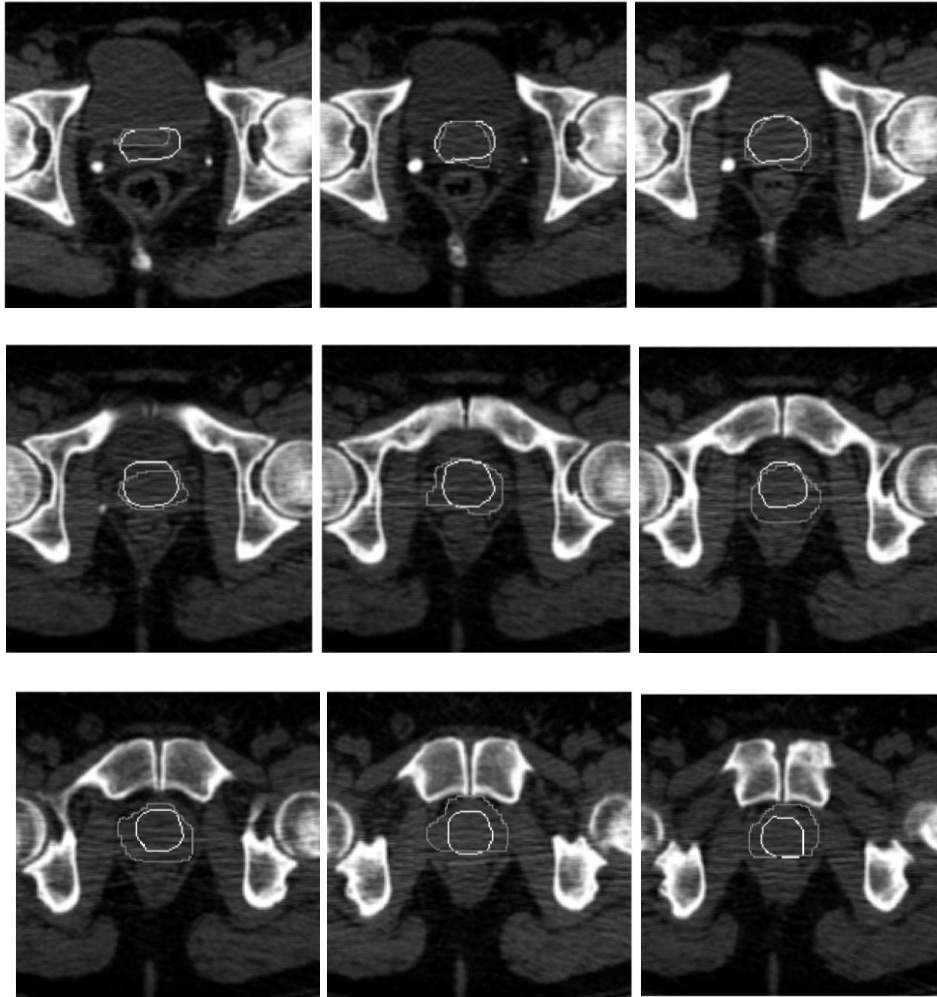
3D segmentation of a CT image using the GA.
